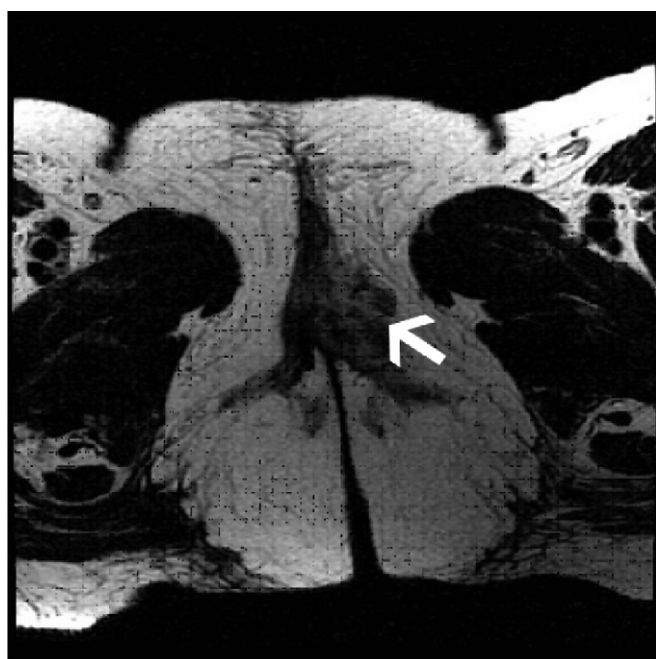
Abdominopelvic magnetic resonance imaging shows a soft tissue mass infiltrated into the left vulvar area (arrow).
